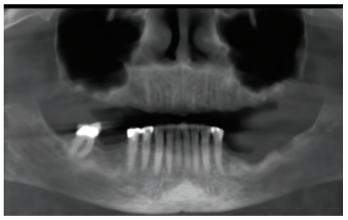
Radiograph taken for implant planning
